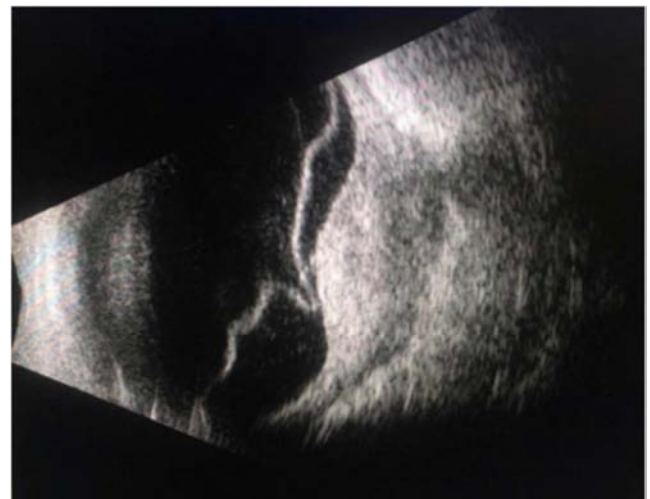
B-scan ultrasonography revealed vitreous cellularity, retinal detachment, subretinal fluid, and a nodular lesion of irregular thickness.
